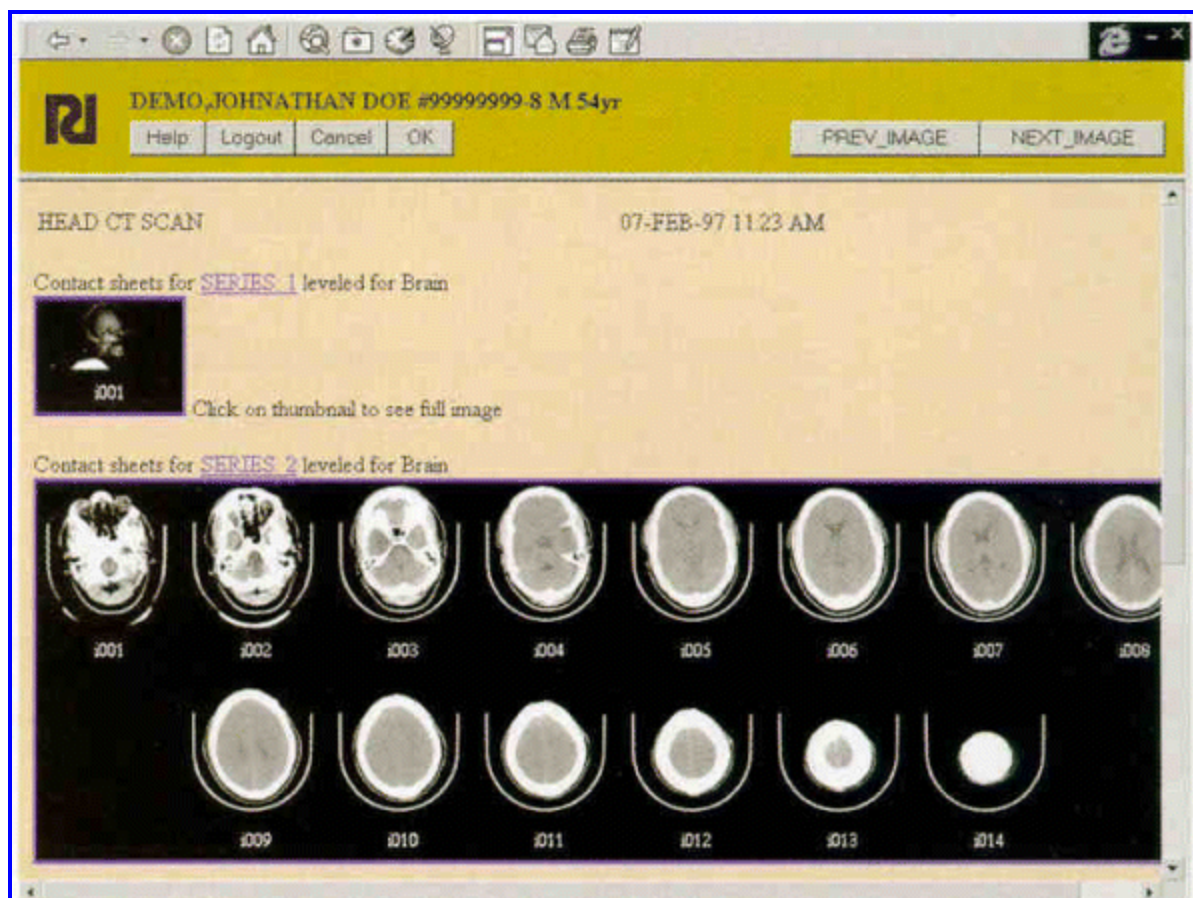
Thumbnail images of CT scan slices displayed through a Web browser on the Regenstrief Medical Record System EMR.
